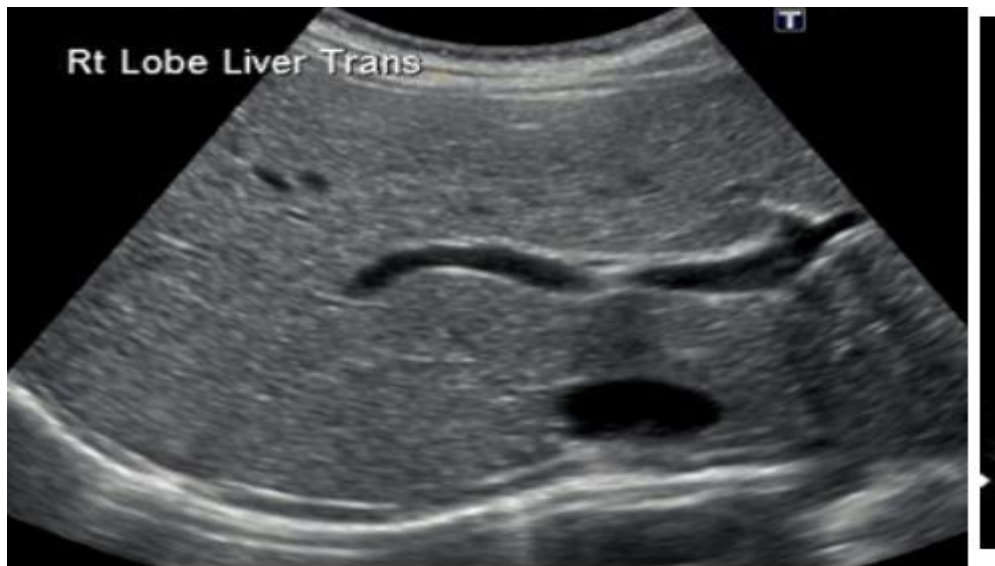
trans abdominal view sonographic feature of PV, (www.ultrasoundpaedia.com 2018) Dr Daniel J Bell ,et al.
